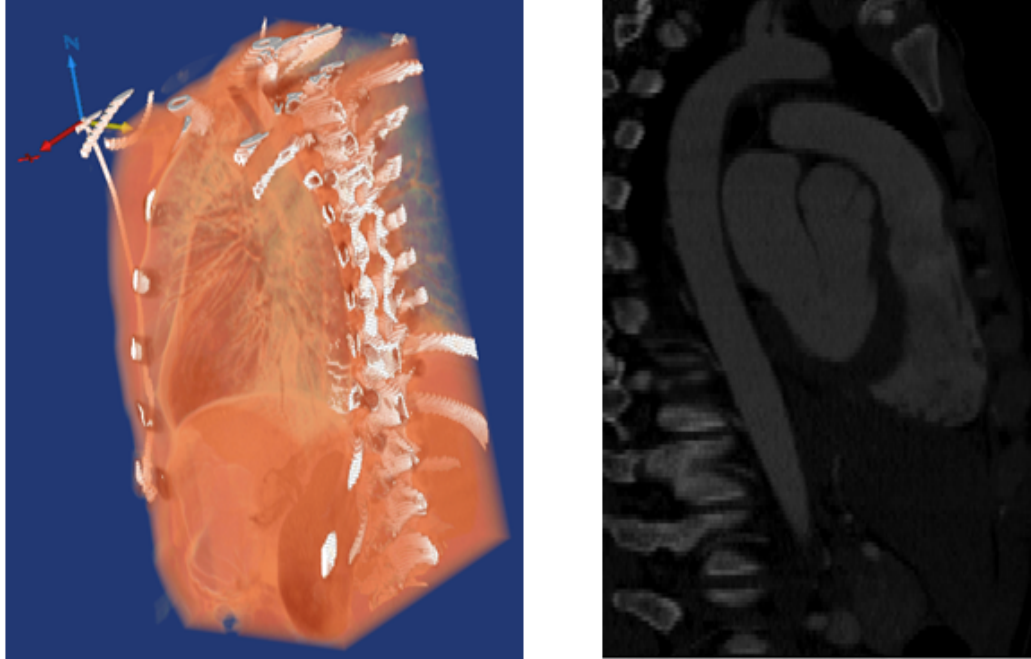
Dicom data and CT image slice (Dicom data courtesy: Radiology Department, IU School of Medicine)
